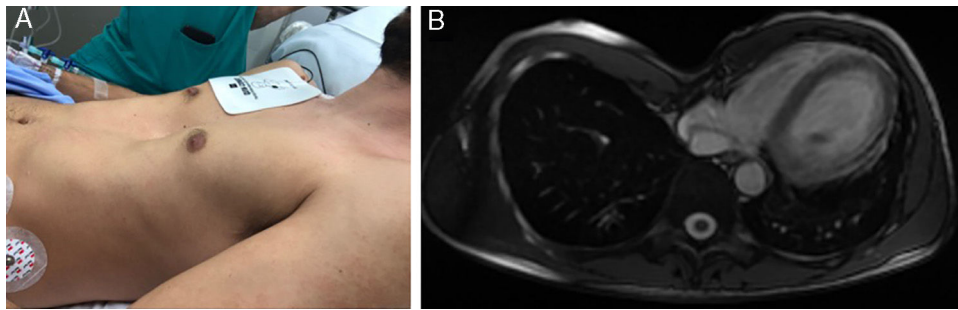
Patient in supine position (A) and cardiac magnetic resonance image (B) showing pectus excavatum.
